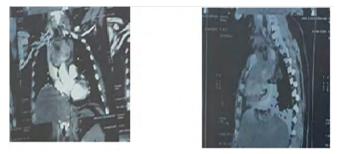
showing forgotten goitre seen in follow up CT chest coronal and sagittal sections
